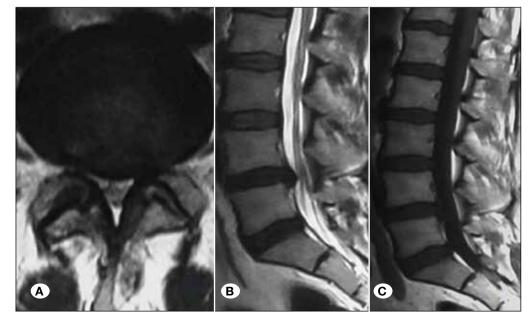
T2 Weighted (A) axial MR image, (B, C) T2and T1-weighted sagittal MR images that reveals contained central disc herniations with an intact PLL and occupying less than 50% of the sagittal intraspinal diameter.
